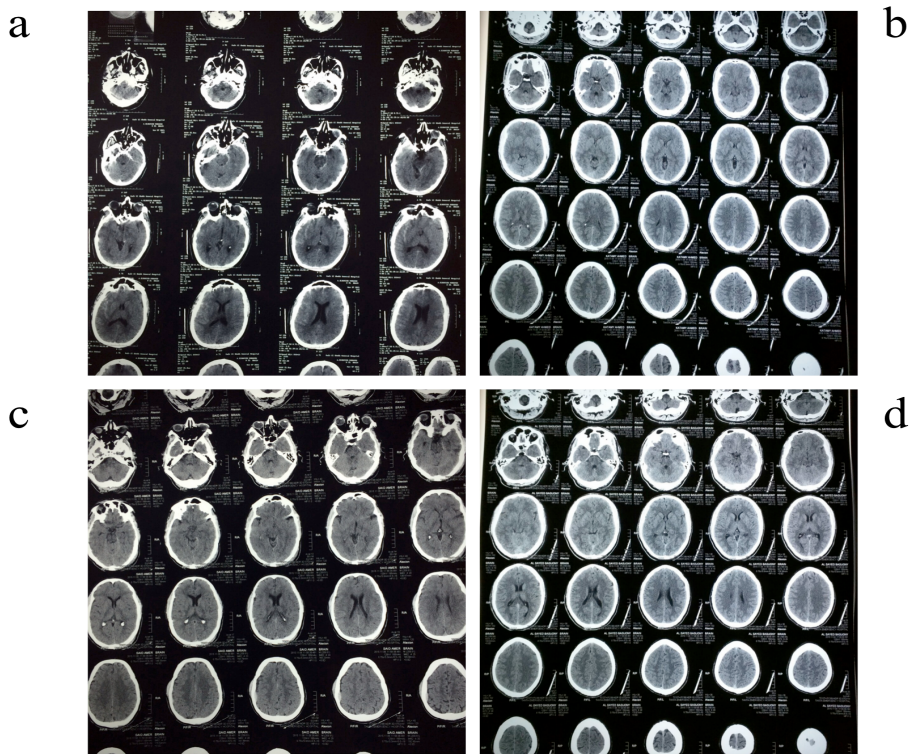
Examples of CT findings in patients: a: Left occipital fissure, subarachnoid hemorrhage; b: Left temporal fissure; c: Right extradural hemorrhage 1 cm; d: Just brain edema.
